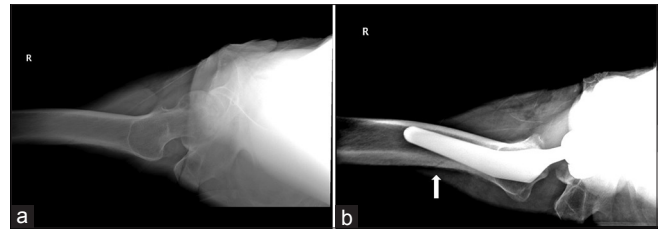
Anteroposterior hip radiographs of a 63-year-old male (a-d). (a) No radiolucent line is seen preoperatively in the femoral diaphysis. (b) A displaced periprosthetic femoral fracture is seen in the proximal one-third of the femur postoperatively. In addition, a longitudinal radiolucency (fracture line) in the medullary cavity is observed from the implant tip. (c) New displaced periprosthetic fracture is developed through the radiolucency seen in (b) due to insufficient fixation of the fracture (c). (d) Reoperation with plate fixation is underwent
